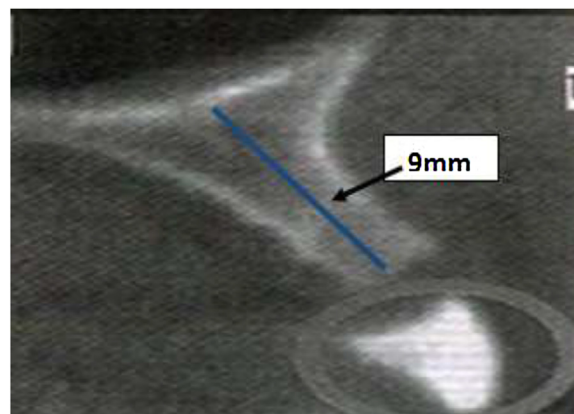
CBCT showing vertical ridge deficiency preoperatively.
